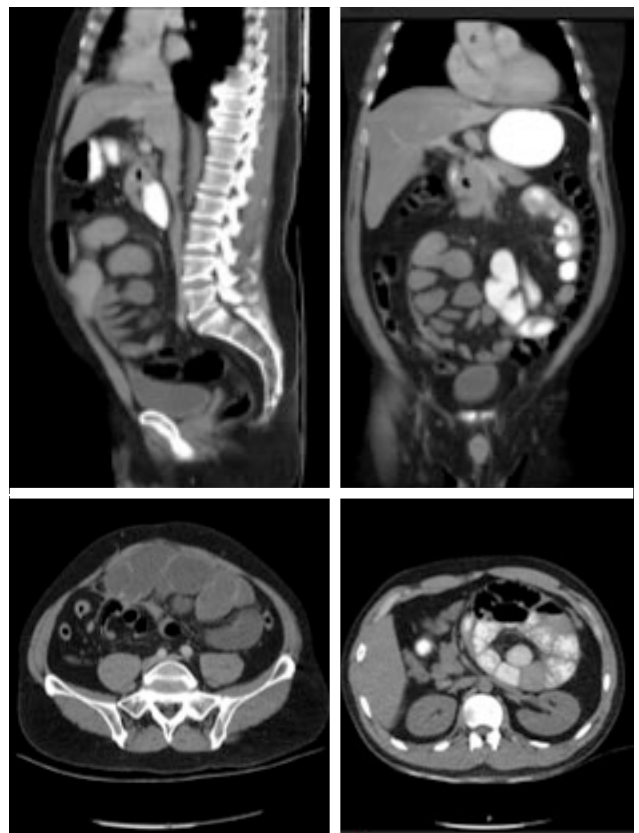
CT images of partially wrapped abdominal cocoon.
